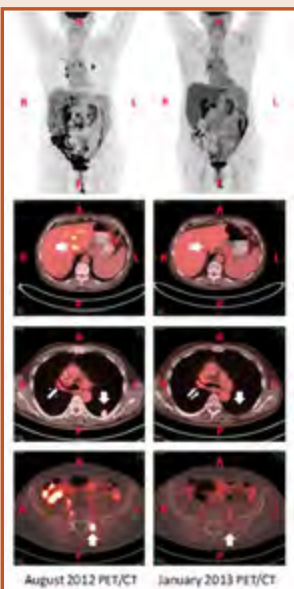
Ipilimumab and local radiotherapy result in an abscopal response. PET imaging and select fused PET/CT axial images from August 2012 (left) and January 2013 (right) are displayed. The axial images in the second row reveal the hypermetabolic liver lesion that was targeted and responded to radiotherapy (white arrows, second row). An abscopal response was seen in a left lower lobe lung lesion (white arrows, third row) and a left sacral lesion (white arrows, bottom row). A mixed response was seen in the hilar/mediastinal lymph nodes (striped arrows, third row).
